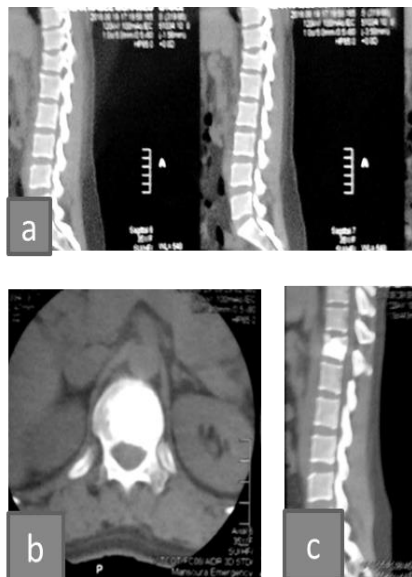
Pre and post operative CT a- preoperative sagittal view b- postoperative axial view showed filling of the fractured vertebra with bone cement with no leakage c- post operative sagittal view show restoration of vertebral height and angles.
